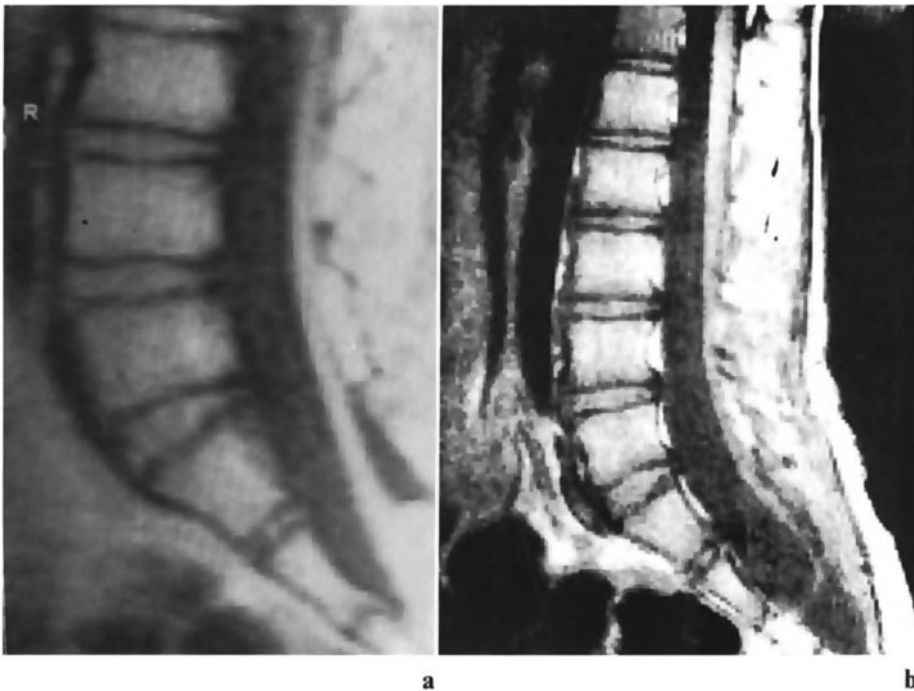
Preoperative and postoperative MRI of a spinal lipoma. (a) The spinal cord is fixed anteriorly to a lipoma located in S2 and S3. (b) After surgery the lipoma has disappeared and the spinal cord is detethered but will remain at the same level
